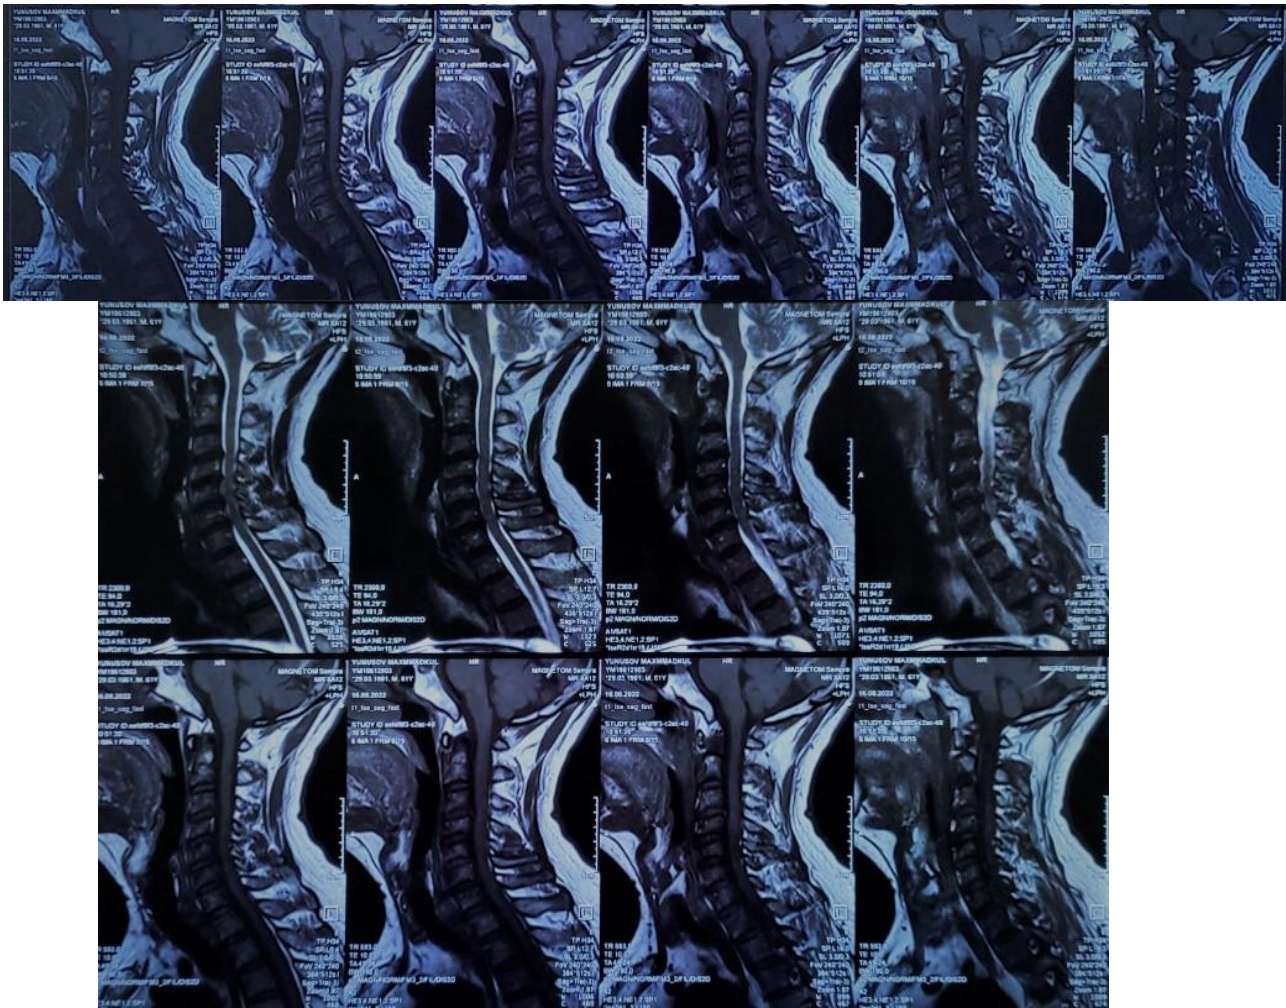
Patient M., August 26, 2022. Magnetic resonance imaging (A. sagittal section, T2 mode; B. sagittal section, T1 mode; S. axial section, T2 mode; D. coronal section, T2 mode) revealed intervertebral disc herniation in VC3-4 (3.0mm), VC4-5 (3mm), VC5-6 (3mm), VC6-7(3.0mm) due to intervertebral disc herniation.
